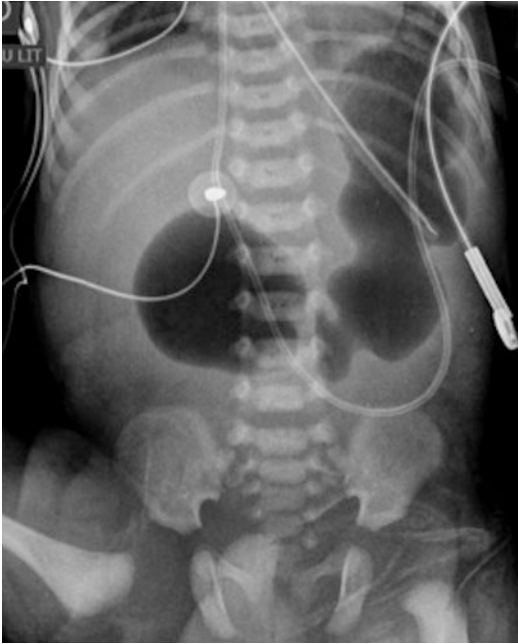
Neonatal abdominal radiograph of a baby showing the typical double bubble sign pathognomonic of duodenal atresia
